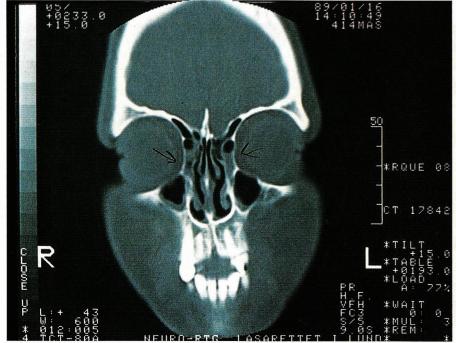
CT-scan of a women with recurrent "maxillary" sinusitis of many years' duration. Confined opacities are seen in the anterior ethmoid (key area) and a moderately swollen mucosa in the maxillary sinus on both sides.
